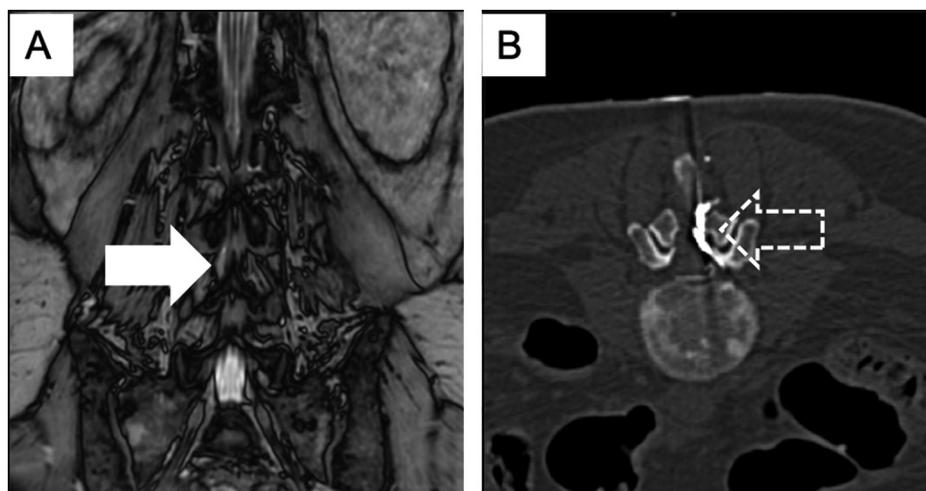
49-year-old woman with history of lung adenocarcinoma and meningeal metastasis presenting with continuous cerebrospinal fluid leakage to the skin. A. T2-weighted MR image in the coronal plane demonstrates cerebrospinal fluid leakage (arrow). B. CT image in the axial plane shows cyanoacrylate glue plugging within the epidural space (dashed arrow).
